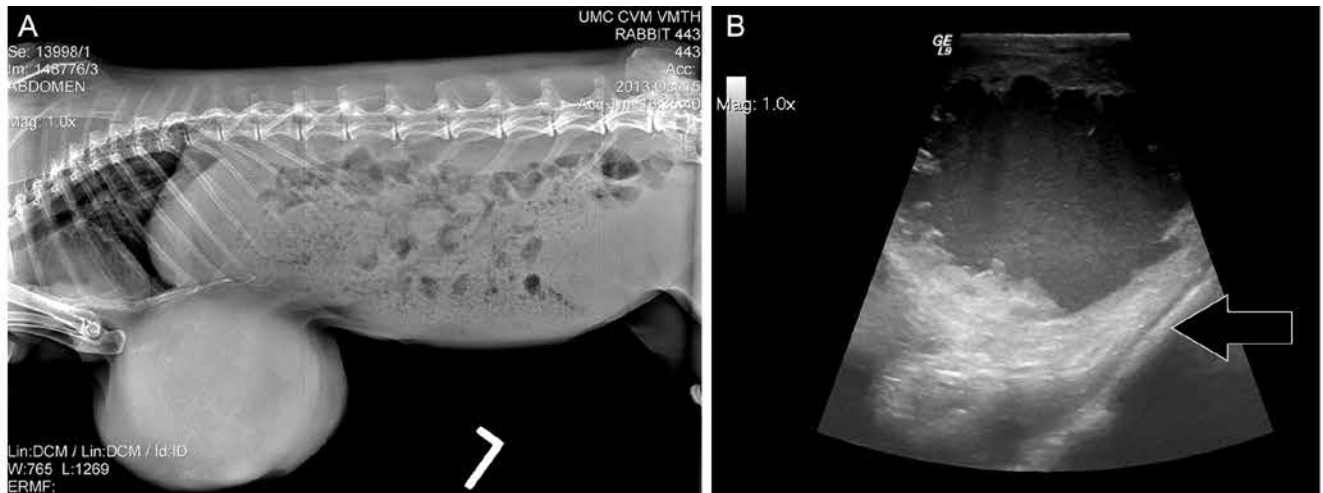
Imaging of the subcutaneous mass. (A) Left lateral radiograph showing the ventral thoracic mass of soft tissue opacity. (B) Ultrasound image revealing a cavitary nature of the mass, with no communication with the pleural space (arrow indicates thoracic wall).
